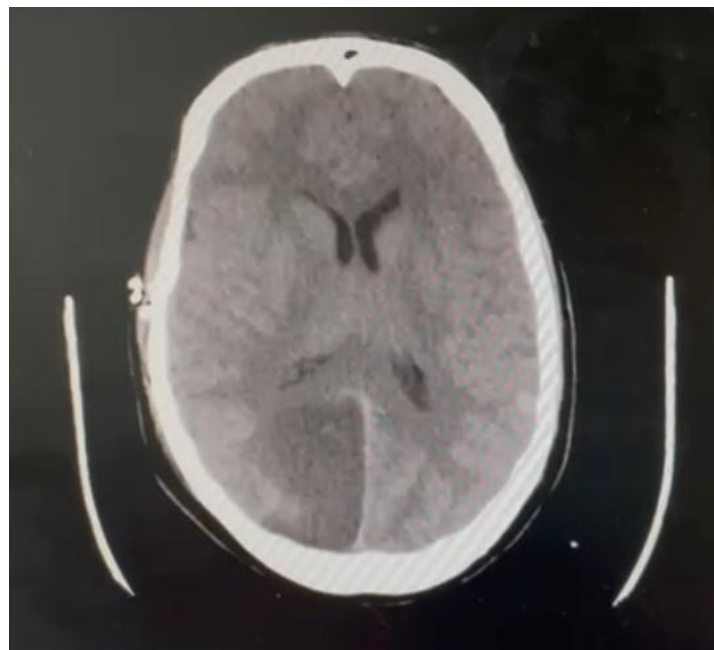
An axial view computed tomography scan without contrast of the brain revealing a right posterior cerebral artery infarction.
